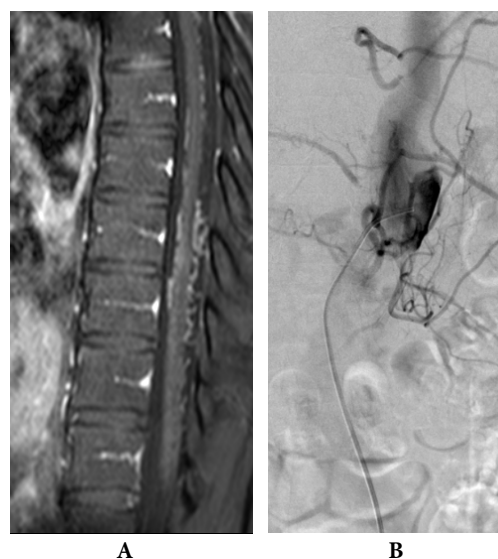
T-10 SDAVF A - MRI - T2; B - Catheter angiography; C - GDC-10 detachment; D - SDAVF occlusion
